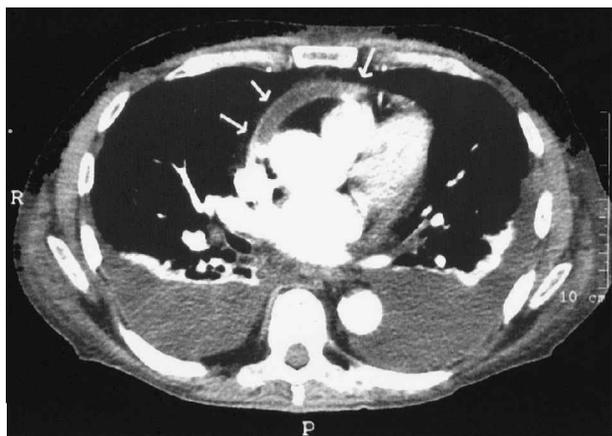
Computed tomography scan showing anterior thickened pericardium (arrow) and bilateral pleural effusions.*
